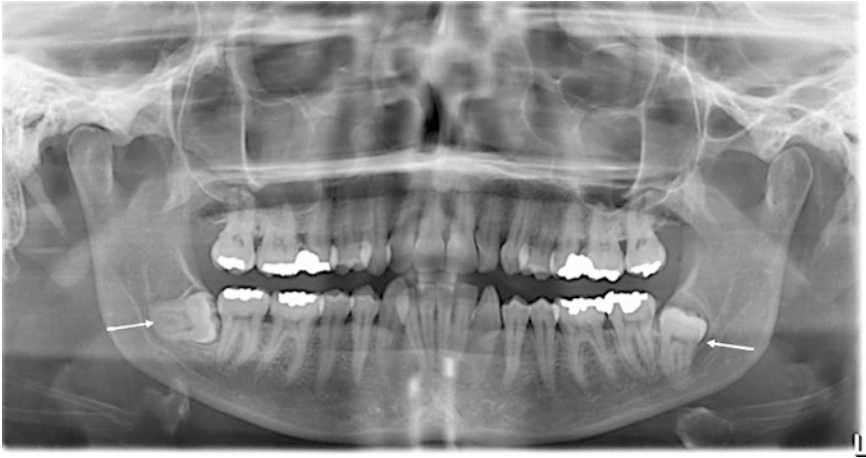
Preoperative orthopantomography: restorations in tooth 1.6, 1.7, 2.6, 2.7, 3.6, 3.7, 4.6, 4.7; mandibular third molars are impacted and dysodontiasic (*arrows*)
